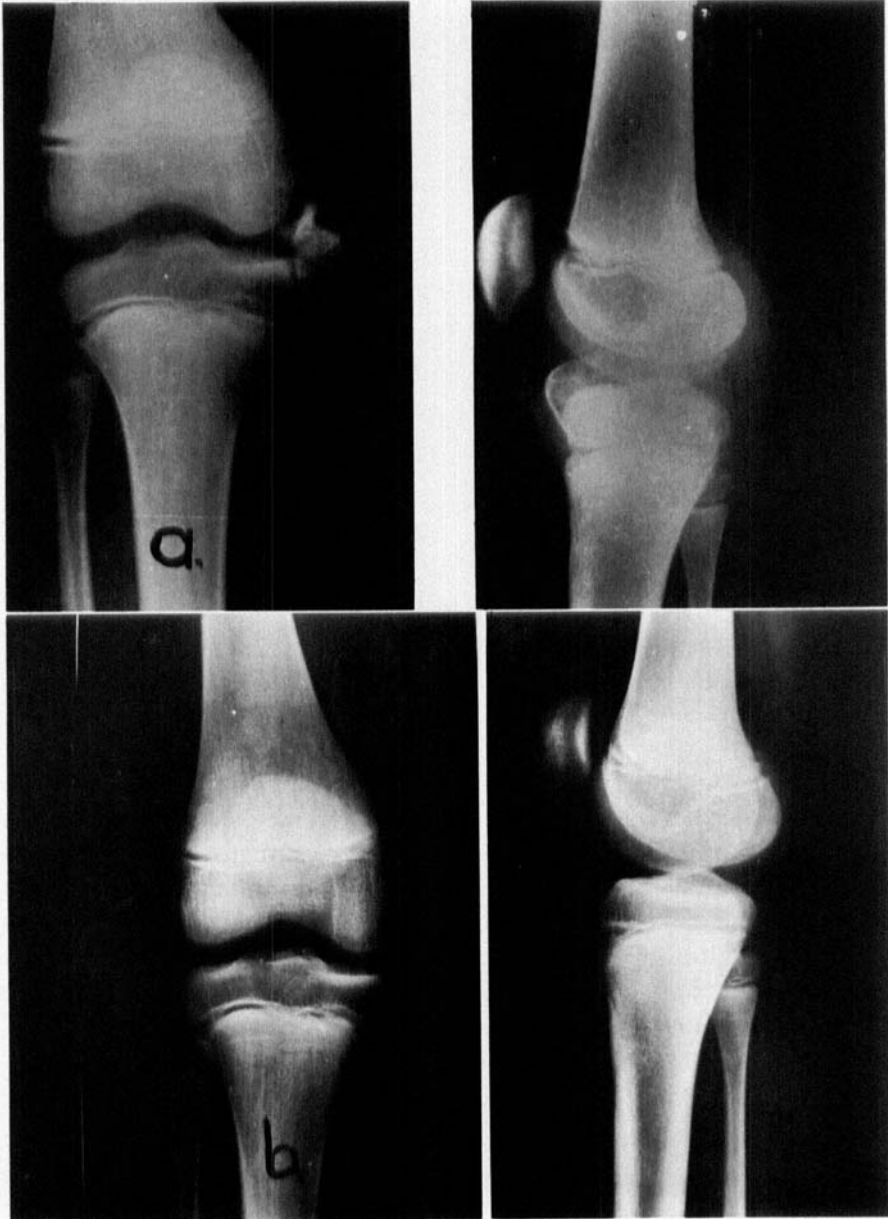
X-ray pictures of the right knee. (a) X-ray picture before operation. (b) X-ray picture after operation.
